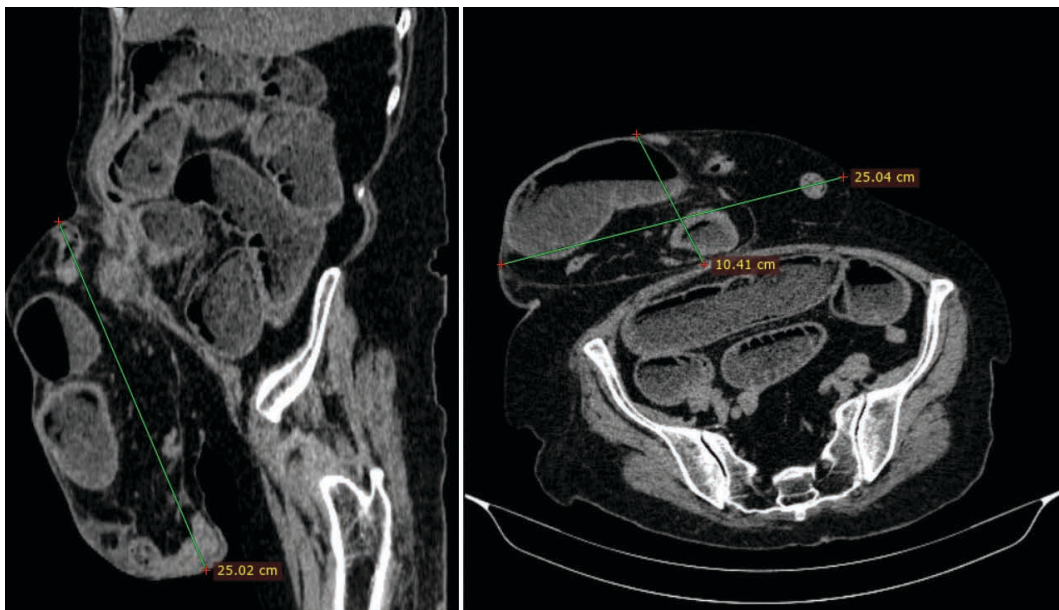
Abdominal CT scans with volumetric assessment of the hernia sac
